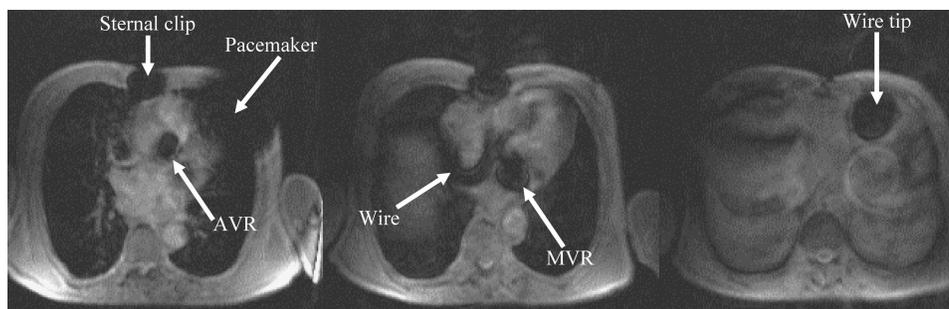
Example of CMR artifacts during cardiac scanning of patient 4 using gradient echo cines at the level of the aortic valve (left), mitral valve (middle) and inferior right ventricle (right). Artifacts are identified with arrows from the pacemaker box, pacemaker lead, sternal wires, the aortic valve replacement (AVR) and the mitral valve replacement (MVR). None of the artifacts prevented identification and quantification of the severe aortic regurgitation and moderate pulmonary regurgitation which were not identifiable by echocardiography in this case.
